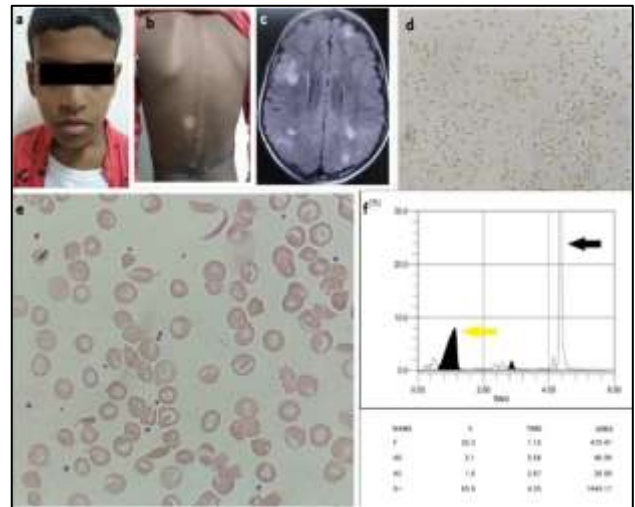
a-b) A 8-year-old boy with clinical features of tuberculous sclerosis such as facial angiofibroma, a and ash leaf macules, c) MRI brain showing numerous cortical tubers, d) sickling test was positive, showing sickle cells, e) peripheral smear showing sickle cells and microcytic hypochromic anemia, f) chromatogram showing a peak in F window of retention time 1.13 minutes (yellow peak) corresponding to Hb F (25.3%) and S window of retention time 4.35 minutes corresponding to HbS 65.9% (black arrow) in HPLC.
